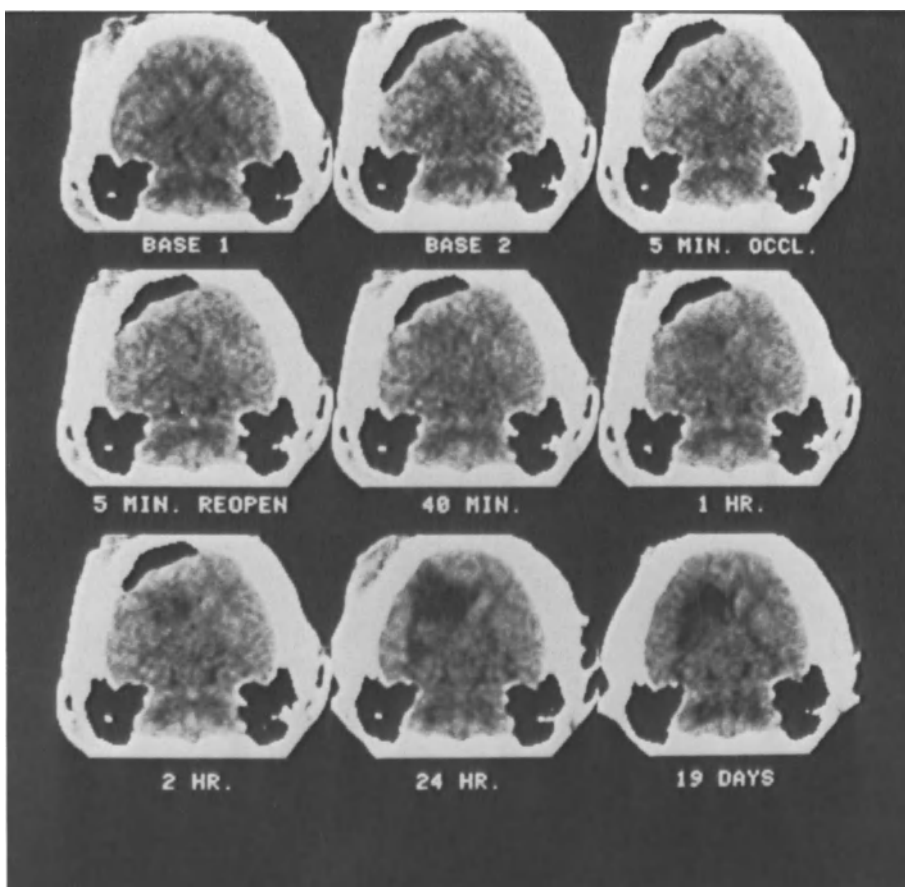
a. Sequential CT scans were obtained prior to, during, and following a one-hour occlusion of the lenticulostriate arteries. Note the appearance of CT low density within two hours after vessel reopening and the progression to encephalomalacia by 19 days
